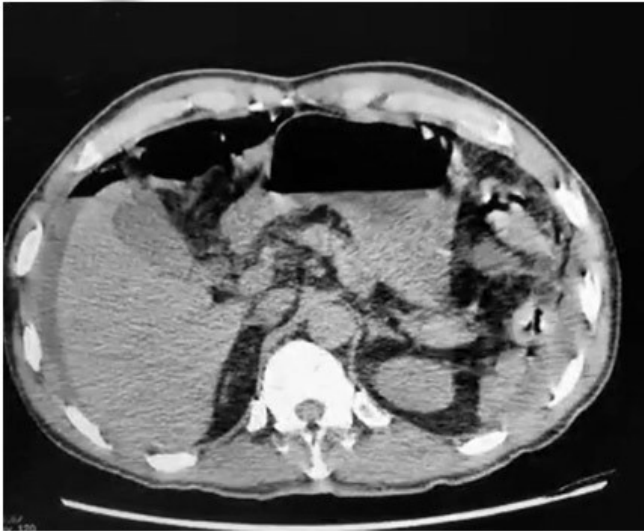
Computed tomography scans of the abdomen showing free air in the abdominal cavity.
